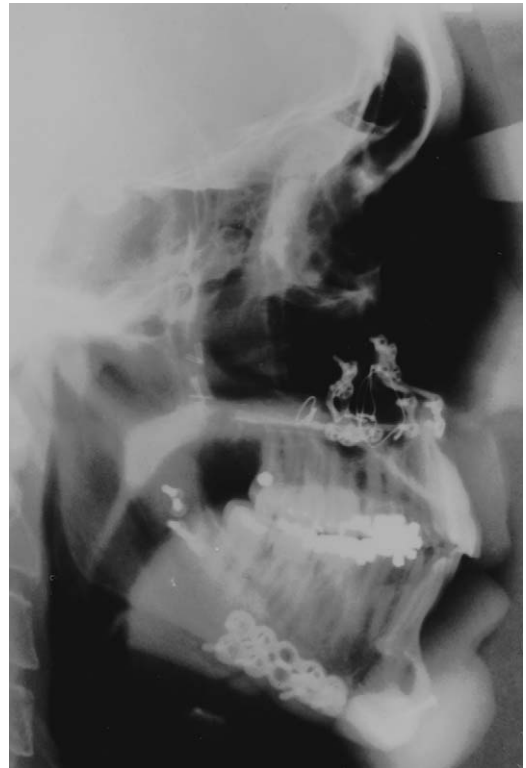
Lateral cephalometric radiograph after maxillo-mandibular advancement.
